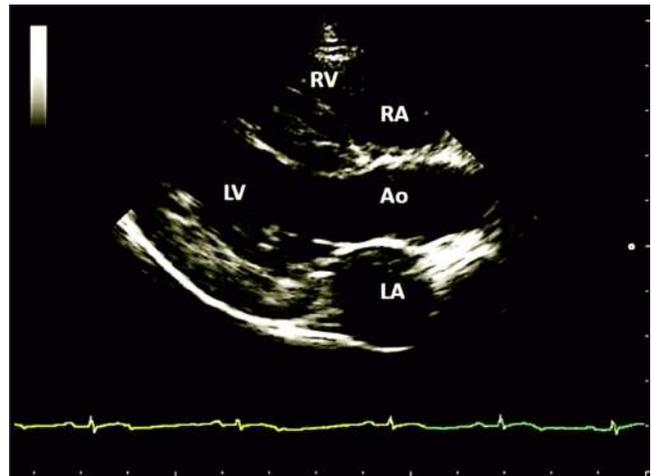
Right parasternal five-chamber view (RV-right ventricle, RA-right atrium, LV-left ventricle, LA-left atrium, Ao-aorta)
